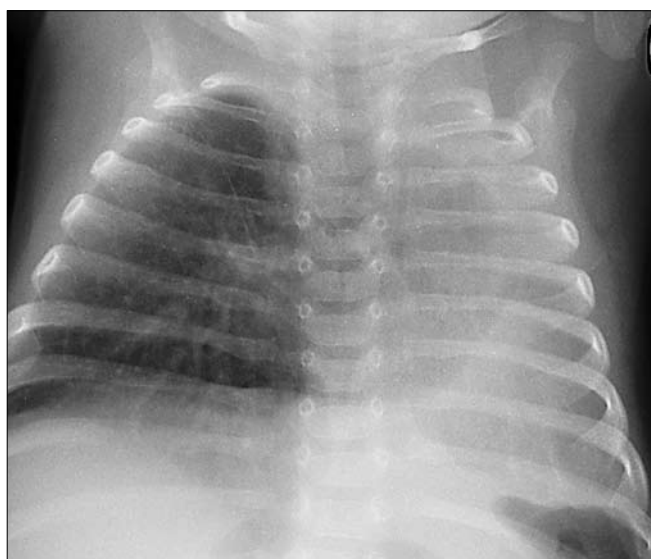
Chest x-ray of the neonate after surgery – day 5 of life.
